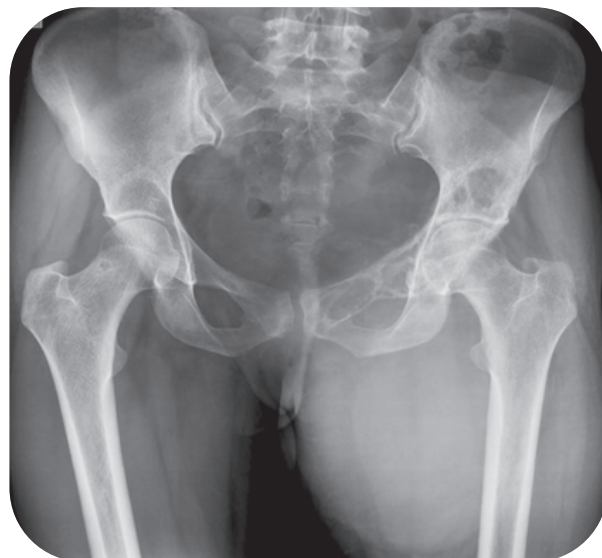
Conventional AP radiograph of pelvis shows lytic expansile lesions of left hemi-pelvis with associated cortical thinning involving superior pubic ramus, iliac wing and acetabular roof. Large soft tissue swelling showing interspersed foci of calcification is seen in left proximal thigh. Underlying left femur appears normal.
